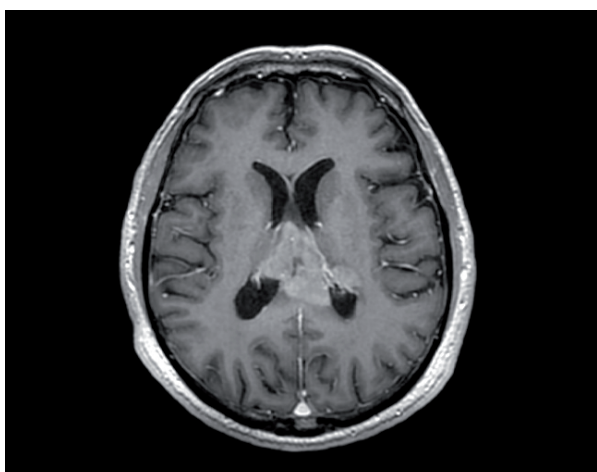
A malignant lymphoma T-1 weighted MRI
